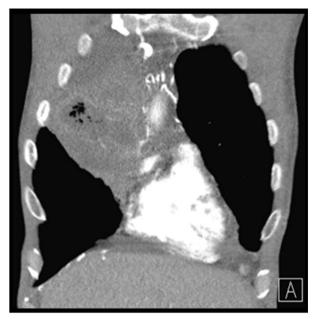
Prior chest computed tomography scan with contrast showing an area concerning for abscess in the right upper lobe.
